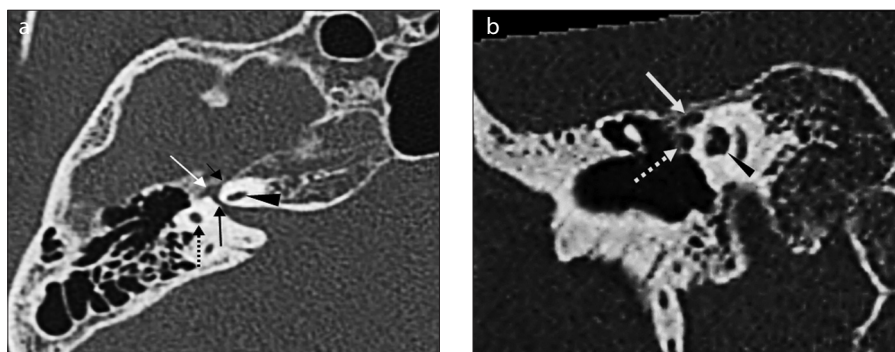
a, b. Anatomy of the right FN on axial (a) and coronal (b) HRCT images. The labyrinthine segment of FN (a, black arrow) is related to the cochlea anteromedially and slightly inferiorly (a, arrowhead) and to the semicircular canal posterolaterally (a, dotted black arrow), and ends at the geniculate ganglion (GG) (a, white arrow). The greater superficial petrosal nerve (GSPN) exits through the facial hiatus (a, short black arrow). The GG/anterior genu (b, white arrow) is related to tensor tympani inferiorly (b, dotted arrow) and cochlea posteromedially (b, arrowhead). It has a bony roof, which can be deficient in up to 18% of cases.
